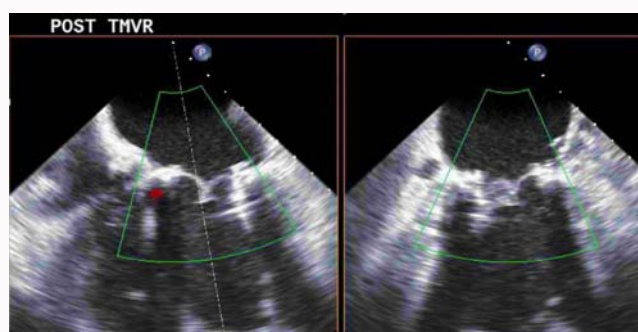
Post-Implantation Transesophageal Echo Showing No Paravalvular Leak.
